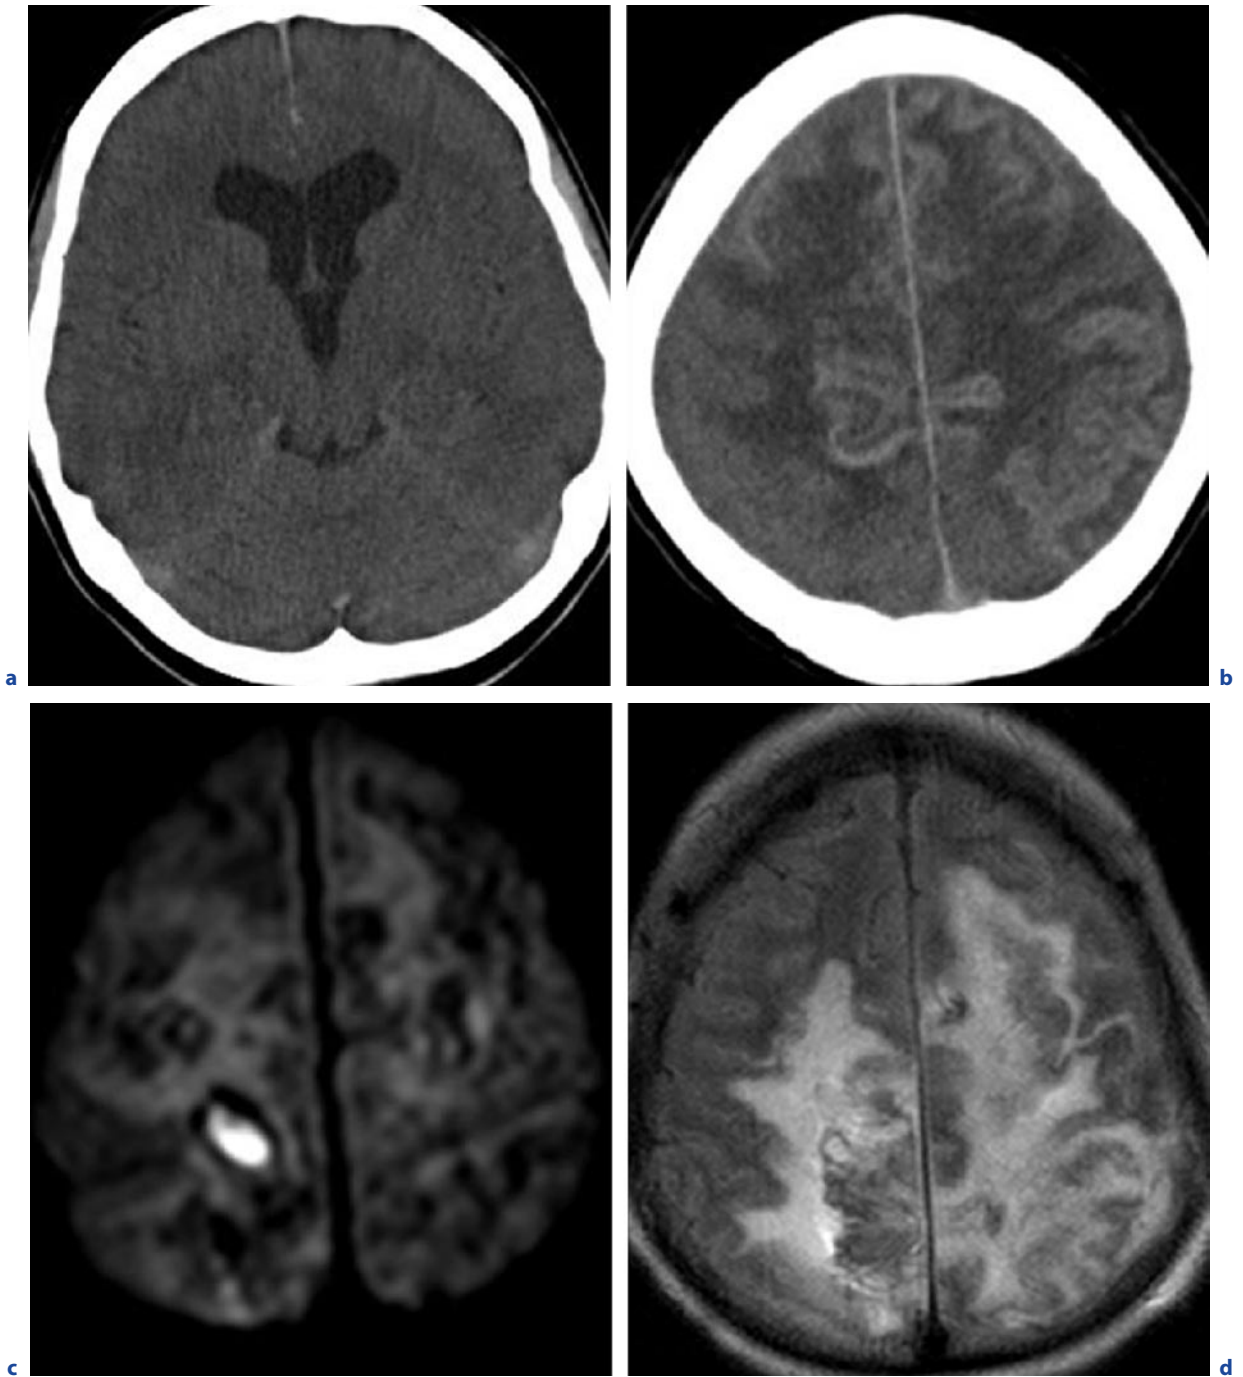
Bacterial meningitis (*Mycobacterium tuberculosis*). A 40-year-old woman with tuberculosis for 15 years. She presented with acute pneumonia and reduced vigilance. a,b Axial CT. c Axial DWI. d Axial FLAIR image. e-i see next pages
